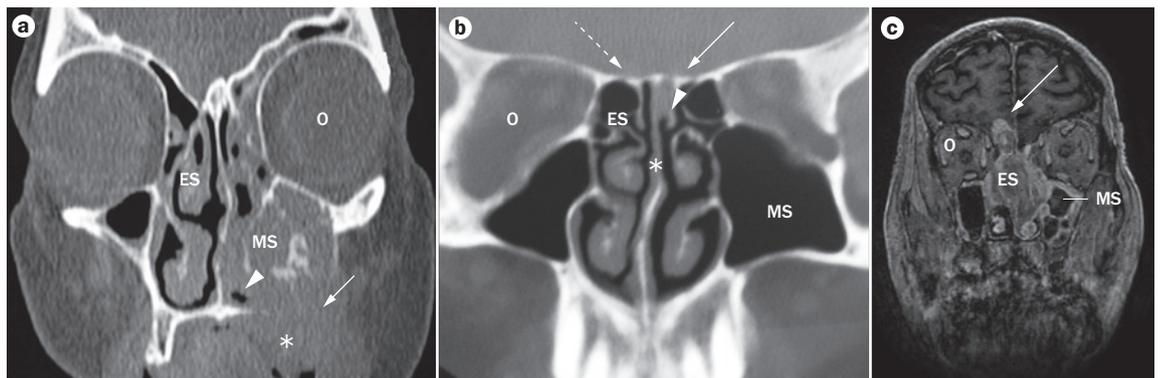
Imaging approaches for diagnosis of sinonasal tumours. CT imaging in axial and coronal sections, preferably with contrast enhancement, enables accurate assessment of sinonasal cancers, especially in terms of bone destruction. Features of malignancy are invasion of soft tissue and the presence of reactive osteogenesis. MRI is generally indicated for assessing extension beyond the sinonasal cavities (orbital, intracranial or infratemporal fossa invasion), evaluating perineural tumour spread, and differentiating tumour from postobstructed secretions. MRI protocols generally include axial and coronal T₁-weighted, T₂-weighted, STIR and T₁-weighted gadolinium-enhanced scans. a | Coronal CT image showing an aggressive left maxillary SNSCC with destruction of the maxillary sinus walls. Erosion of the floor of the maxillary sinus and extension of the tumour into the maxillary alveolus (arrow), buccal space (asterisk), and hard palate (arrowhead) is evident. b | Coronal CT image of a woodworker, which led to the early diagnosis of a small ITAC of the left olfactory cleft (arrow). The left olfactory cleft is closed by a slight bulging of the corresponding nasal septum (asterisk) to the right and of the conchal lamina (arrowhead) to the left. Note the thinning of the left cribriform plate (dotted arrow). c | 3D IR-prepared gradient-echo sequence coronal MRI image demonstrating a large, heterogeneous ITAC occupying the nasal cavity and ethmoid sinuses bilaterally, with extension into the anterior cranial fossa (arrow). Abbreviations: ES, ethmoid sinuses; IR, inversion recovery; ITAC, intestinal-type adenocarcinoma; MS, maxillary sinus; O, orbit; SNSCC, sinonasal squamous-cell carcinoma; STIR, short tau inversion recovery.
